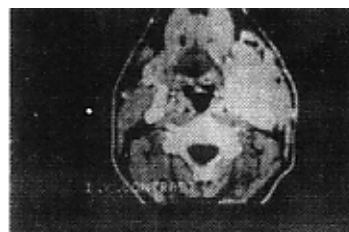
CT scan showing a carotid body tumour
